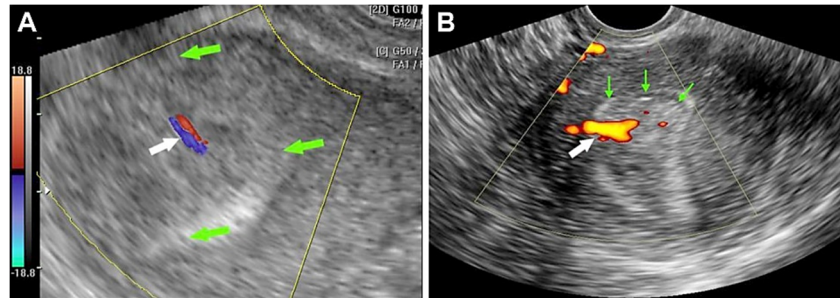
Three-dimensional transvaginal ultrasound demonstrating endometrial polyp (green arrows) and the uterus external contour (white arrow).
